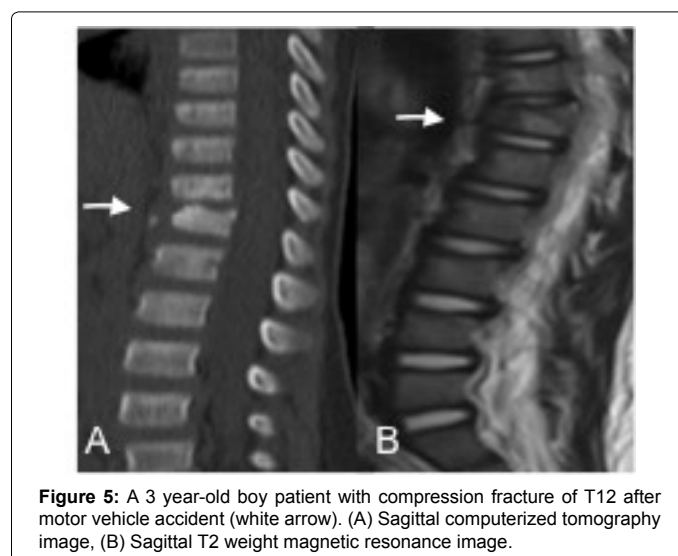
A 3 year-old boy patient with compression fracture of T12 after motor vehicle accident (white arrow). (A) Sagittal computerized tomography image, (B) Sagittal T2 weight magnetic resonance image.
